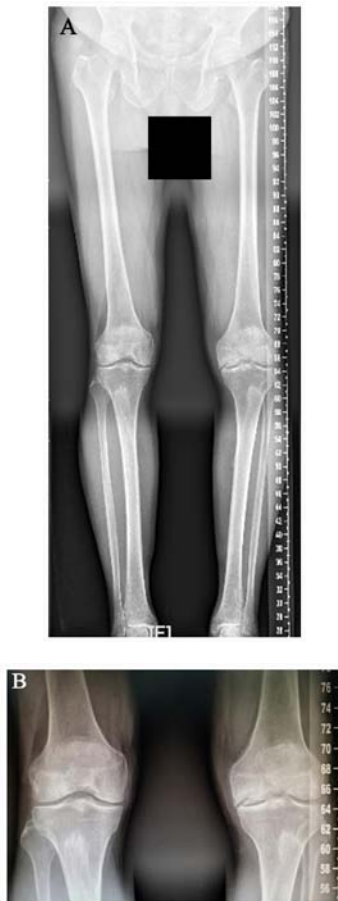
Long standing anteroposterior X-ray prior to the second surgery. (A) Compared with the right knee, the left knee became valgus because of the collapse of the medial femoral condyle. (B) The joint space of the left knee became narrow.
